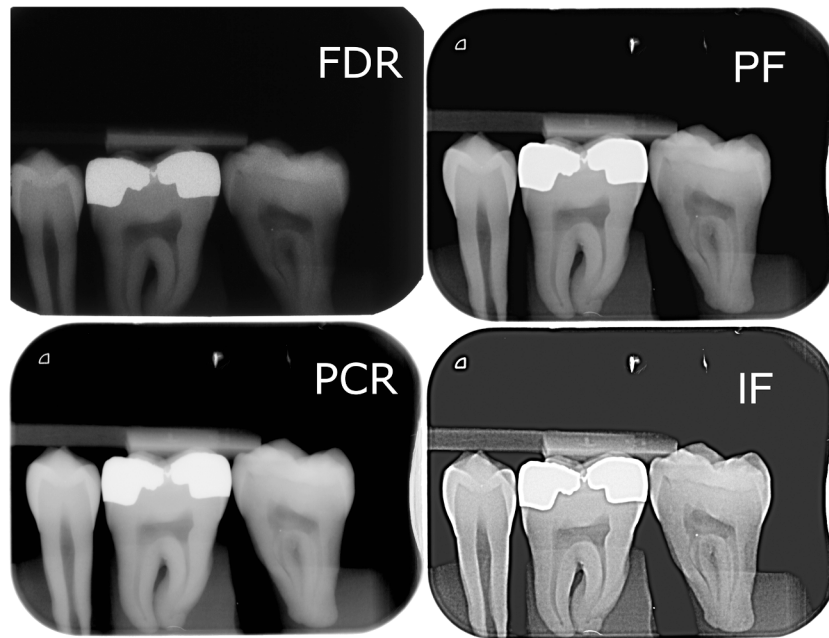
The mounting device ensures standardized bitewing radiographs with perpendicular alignment of the tube to the film. The fillings were put in contact with adjacent teeth.
